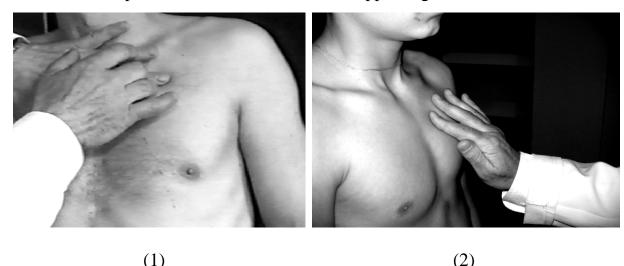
Percussion of the superior border of the relative heart dullness: (1) 1-t step – percussion by interspaces on the left parasternal line; (2) 2-d step – immediate percussion by two ribs overlying the dulling interspace.
